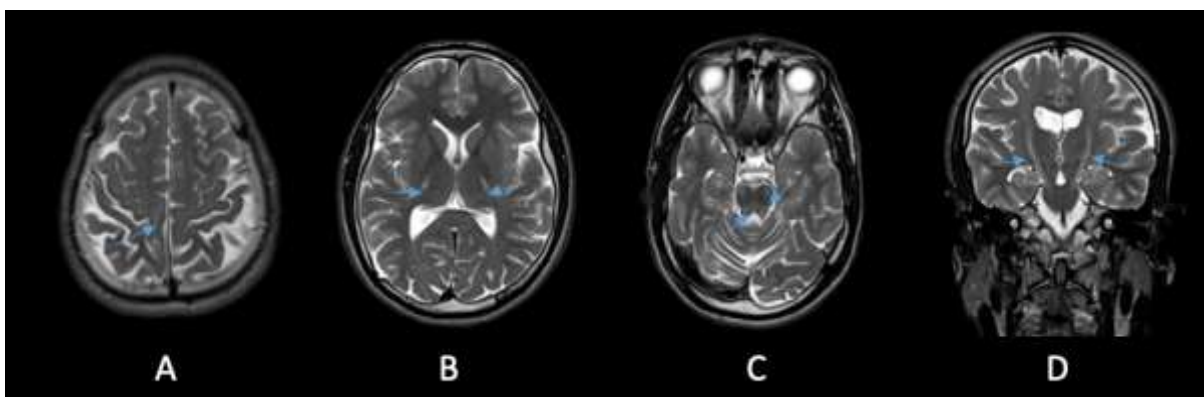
(Case 5) MRI of brain taken at 25 years of age. A–C: Axial T2-weighted images showing hyperintensity of corticospinal tracts (arrows) bilaterally from perirolandic cortex (A) throughout posterior limb of internal capsule (B) reaching the pontine level (C); visible atrophic changes of cerebellum (C) and parietal lobes on brain convexity (A); also presenting signal alteration at posterior pontine tegmentum and both superior cerebellar peduncles (C). D: coronal T2W image showing bilateral involvement of corticospinal tract.
